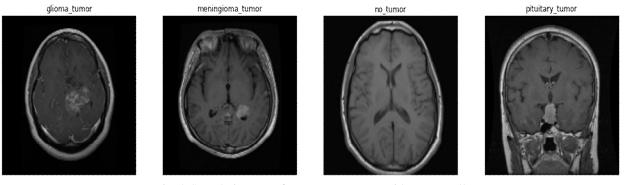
Sample images of MRI scan reports with tumor cell
